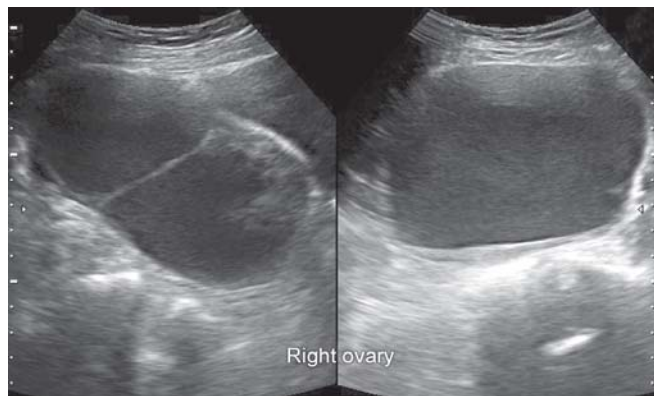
Echogenic cystic lesions with thin septations are usually benign hemorrhagic lesions. Occasionally, however, these may be pathologic surprises and should be assessed with power and color Doppler to confirm a benign pattern as shown in figure 50
